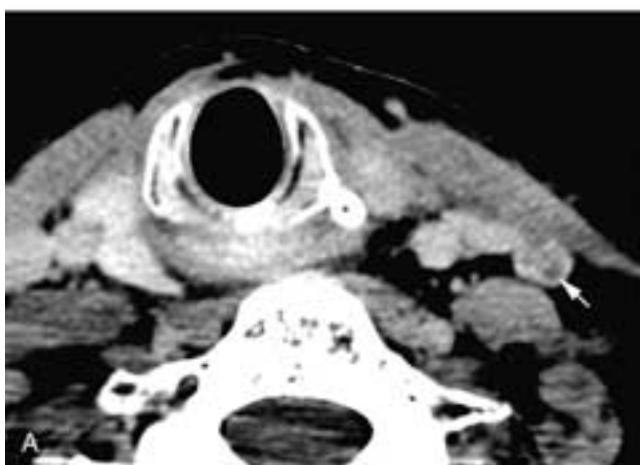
Axial contrast-enhanced CT scan (A) shows a 1-cm left level III node with focal areas of low attenuation (*arrow*) in the subcapsular region. Axial contrast-enhanced CT scan (B) on another patient shows an enlarged, enhancing right level III node with focal areas of subcapsular low attenuation. There is also enhancement of a hazy-appearing nodal rim indicating extracapsular tumor spread. Both of these nodes contained metastatic squamous cell carcinoma. (Courtesy of Dr. Anthony Mancuso.)
